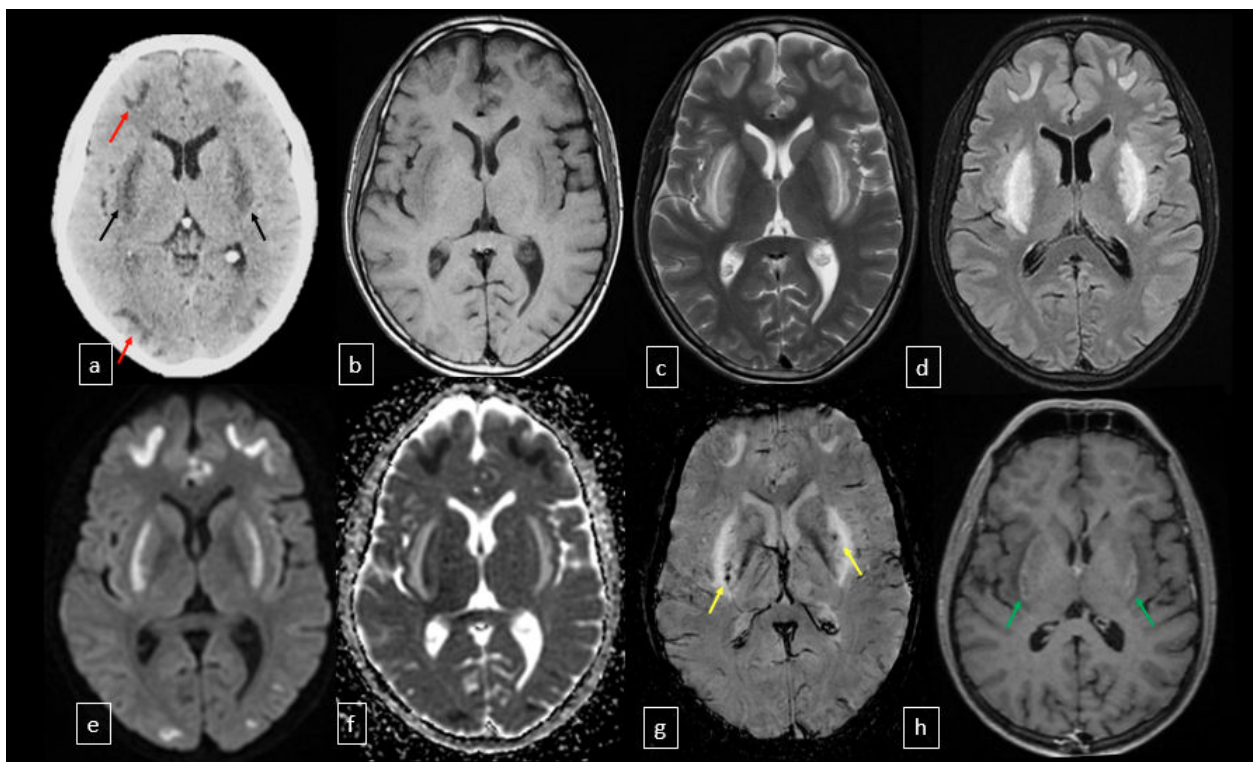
A 40-year-old male with chronic alcohol dependence presented to us with acute bilateral visual diminution, epigastric discomfort, and altered sensorium after a binge involving illicit liquor. Examination revealed a dehydrated male in encephalopathy without meningeal irritation, focal deficits or extrapyramidal involvement. Fundus showed bilateral papilledema. Non-contrast CT scan (Figure 1a) showed hypodensities involving putamen (black arrows) and subcortical white matter (red arrows), which were hypointense on T1-weighted (T1W) MRI (Figure 1b), hyperintense on T2 weighted image (Figure 1c) and FLAIR (Figure 1d). Diffusion restriction and microhemorrhages were seen on diffusion-weighted imaging (DWI) (Figures 1f, g) and susceptibility weighted imaging (SWI) (Figure 1g (yellow arrows)). T1W post-gadolinium images showed peripheral putaminal enhancement (Figure 1h, (green arrows)). Ethanol supplementation led to gradual resolution of encephalopathy but not visual loss, over a period of two weeks. Accumulation of methanol metabolite formate leads to specific endorgan damage [1]. Fomepizole and ethanol are useful antidotes [2].
